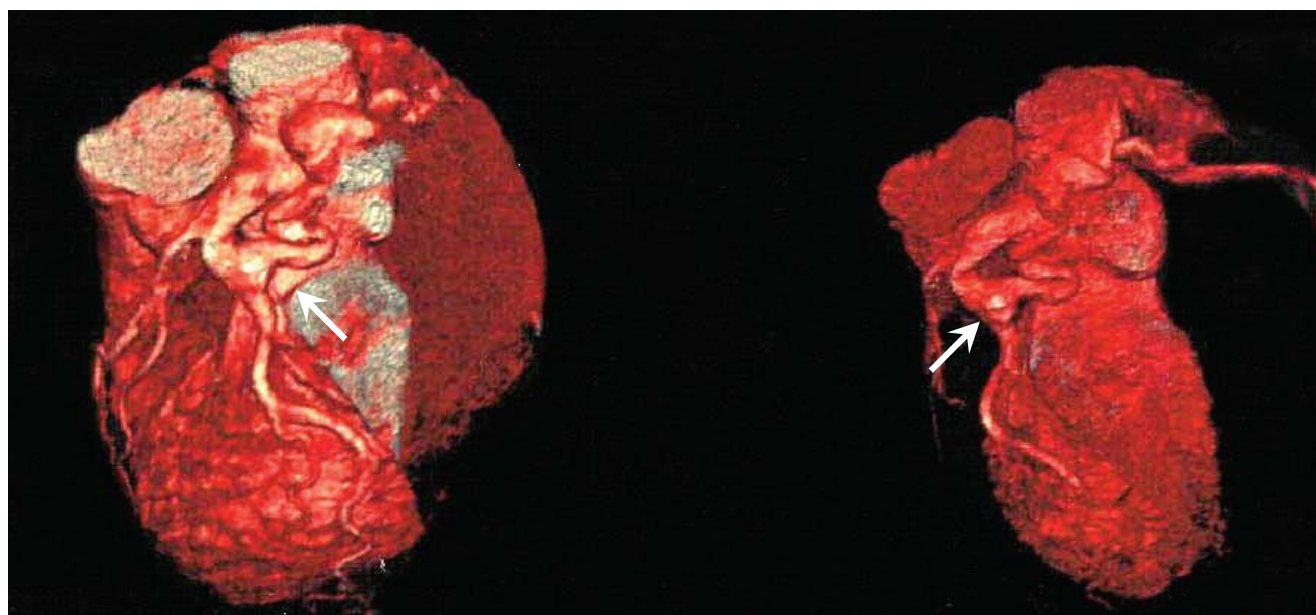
Preoperative CT coronary angiography showed that left circumflex coronary artery was dilated, ectatic with the fistula to the coronary sinus (arrows)
